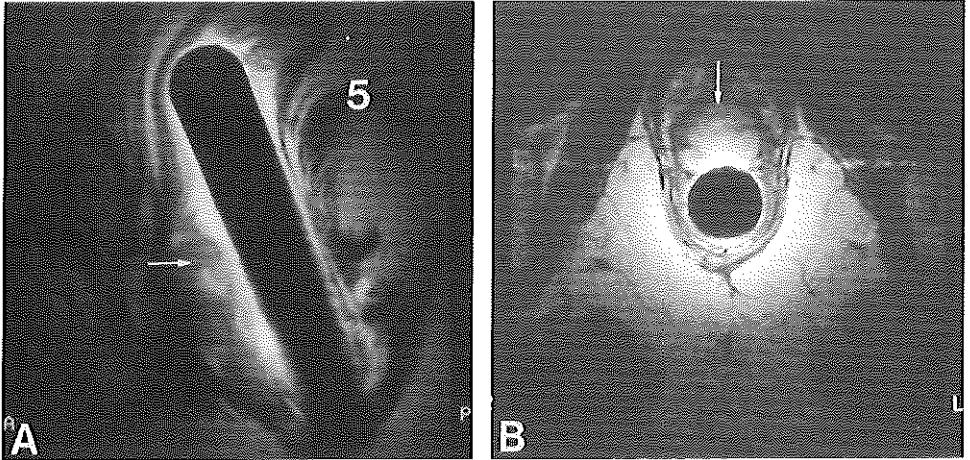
Sagittal (A) and axial (B) endoanal MRI. The tumor (arrow) is located entirely below the level of the levator ani (5).
